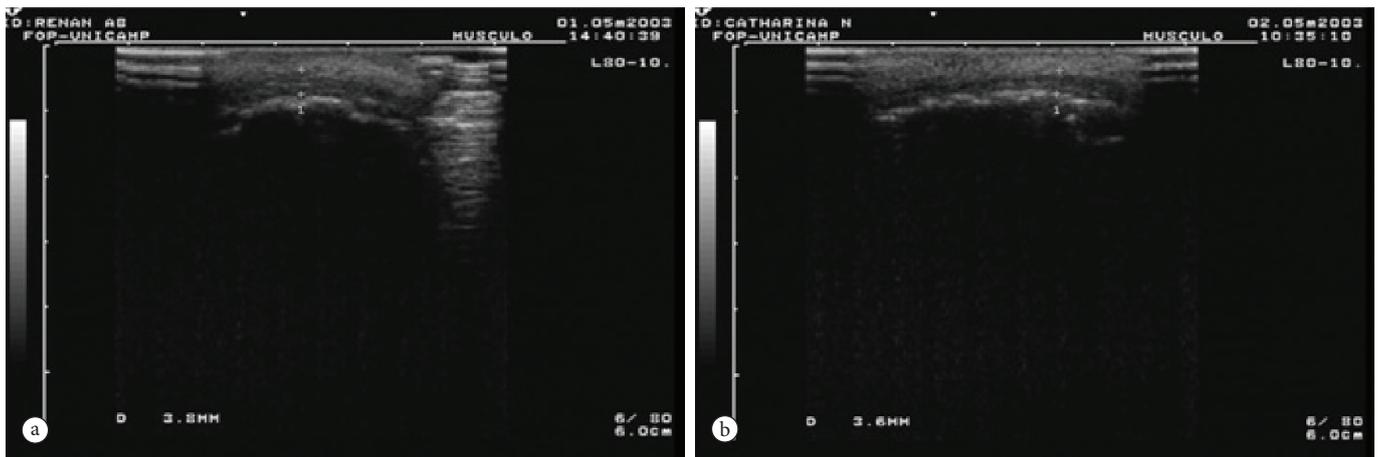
Ultrasonographic image of the upper (a) and lower (b) fascicles of the *orbicularis oris* muscle thickness in the contracted and rest states, respectively.
